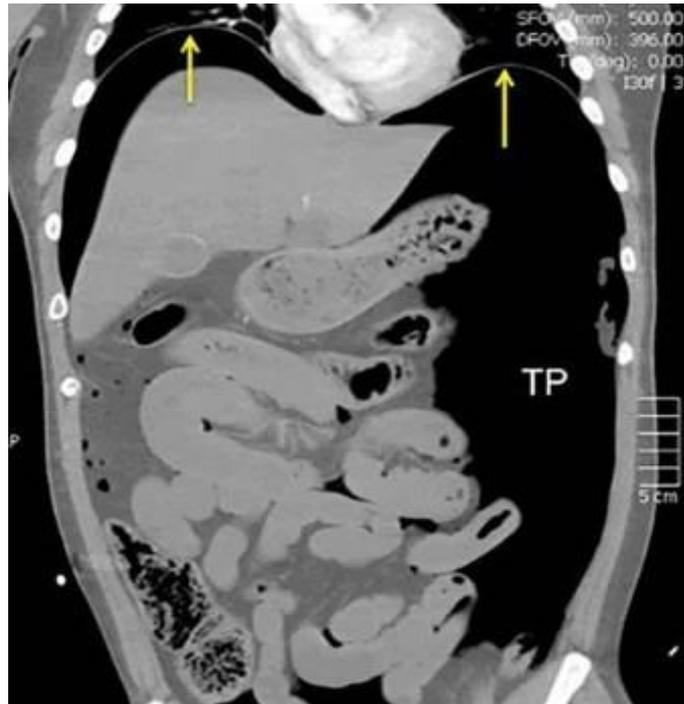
Coronal CT massive pneumoperitoneum with abscess formation(52)
